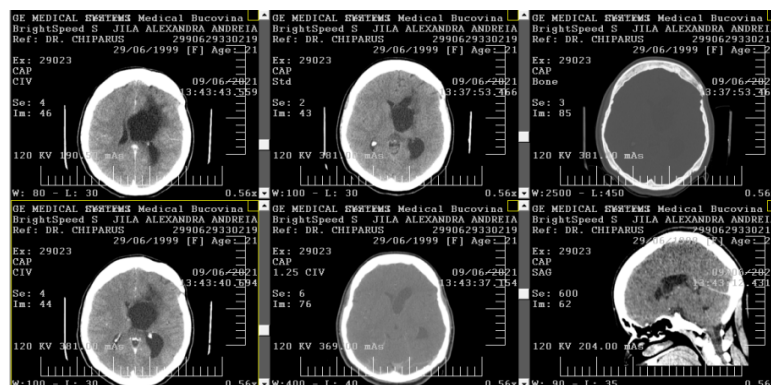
CT examination at 9 months after surgery (from the patient's imaging investigations)
